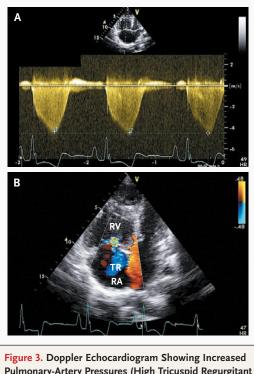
Doppler Echocardiogram Showing Increased Pulmonary-Artery Pressures (High Tricuspid Regurgitant Jet Velocity) and Right Heart Failure in a Patient with Sickle Cell Disease and Pulmonary Hypertension.
